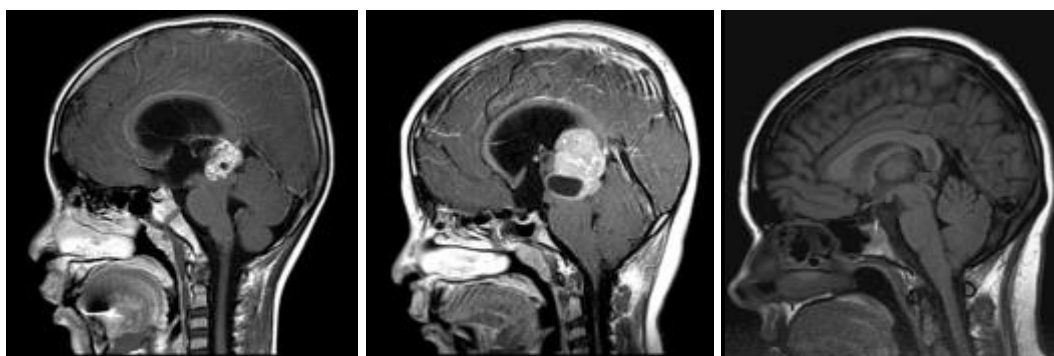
MRI scans showing different pineal tumors (A) Sagittal T1 of Pineocytoma (B) Sagittal T1 view of Pineal Germ cell body tumor [non-germinomatous]. (C) Sagittal T1 view of Pineal germinoma
